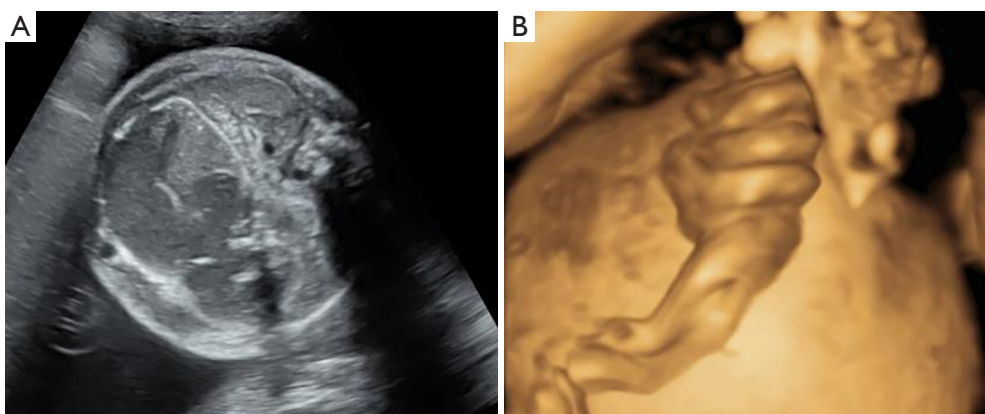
The fetal intraperitoneal mass gradually increased and three-dimensional ultrasound revealed a high torsion of the fetal cord.
